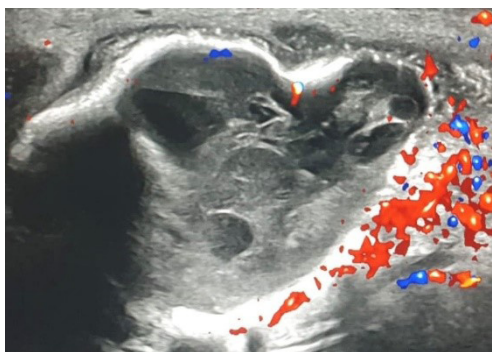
Ultrasound of the right-sided scrotal sac region showed presence of a mixed echogenicity space occupying lesion adjacent to the right testicular prosthesis with internal spill and cystic areas and showed minimal internal and some peripheral vascularity. There was a calcified curvilinear rim around the lesion.
